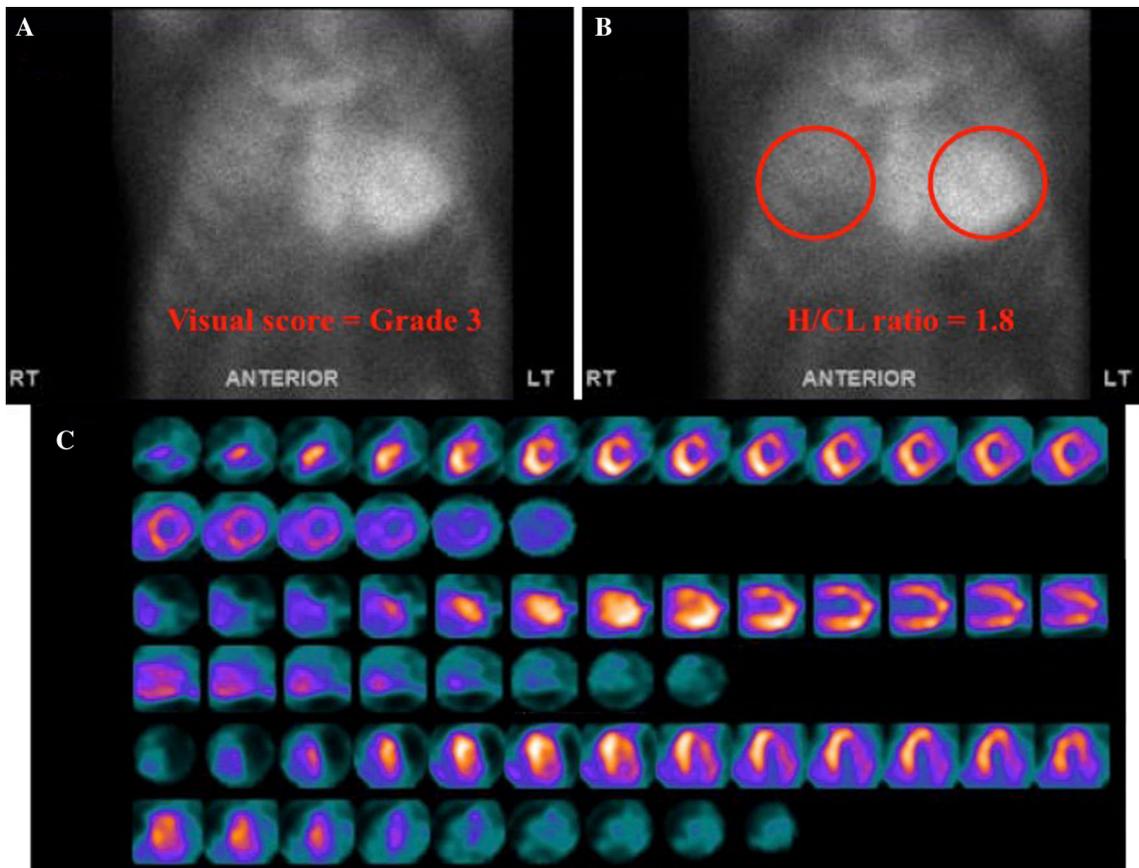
Positive Technetium-99m pyrophosphate (PYP) imaging. A Planar images showing prominent cardiac uptake of Tc-99m PYP at 1 hour after tracer injection. Semiquantitative visual score of radioisotope uptake in the myocardium is Grade 3 (myocardial uptake > rib uptake), B Heart-to-contralateral lung (H/CL) ratio is 1.6 at 1 hour after tracer injection, and C Tomographic reconstruction of SPECT myocardial perfusion images confirming significant myocardial uptake of the isotope, with no blood pool activity.
